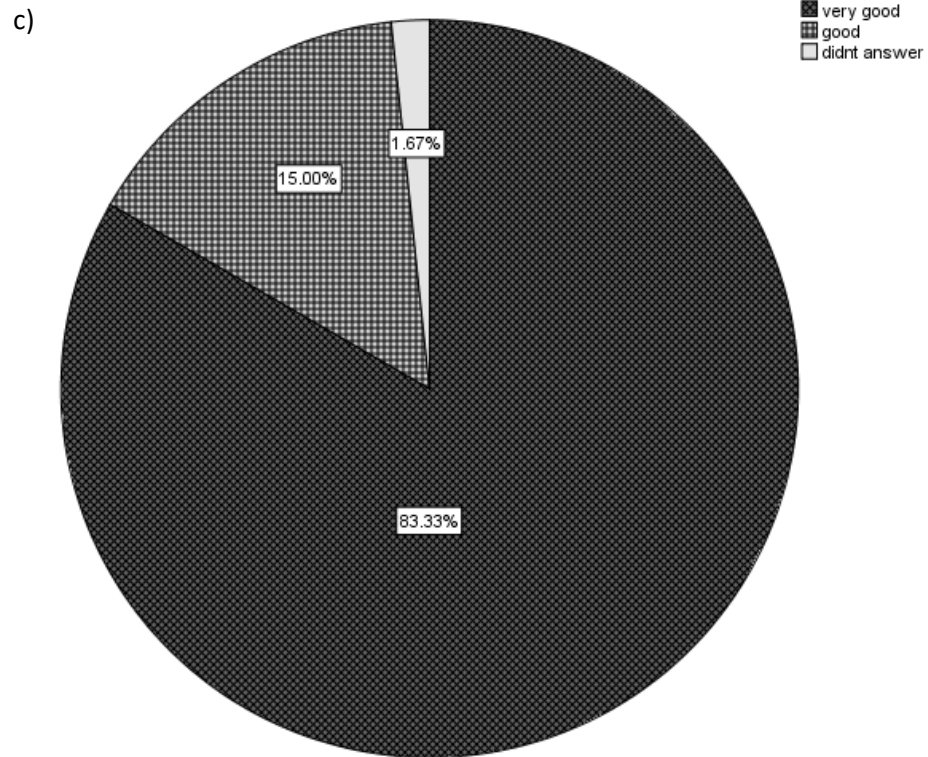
Overall experience of The IAS given by radiographers
